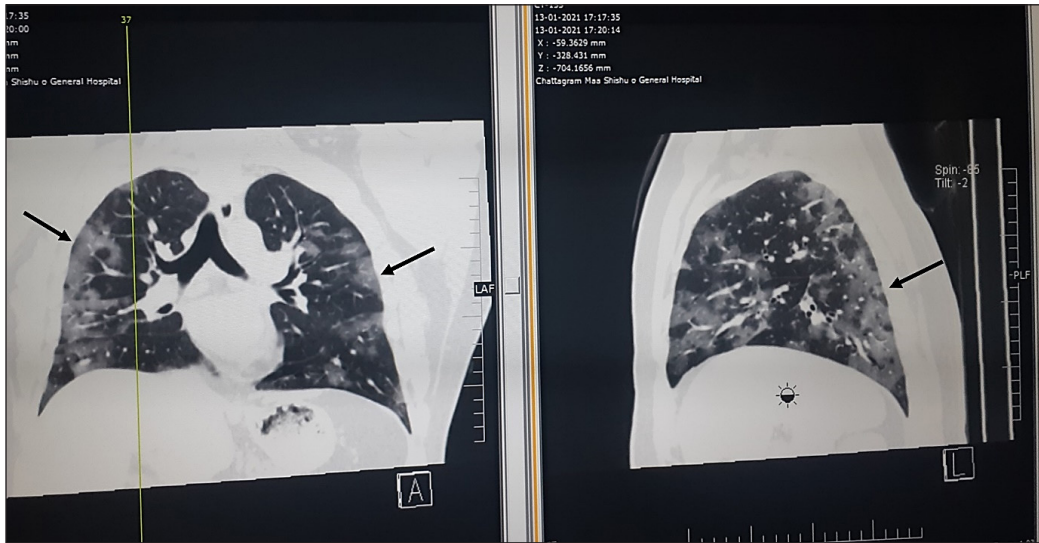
Bilateral multifocal subpleural peripheral ground glass opacities with a crazy paving appearance at all lobes of both lungs - typical COVID-19 CT findings
